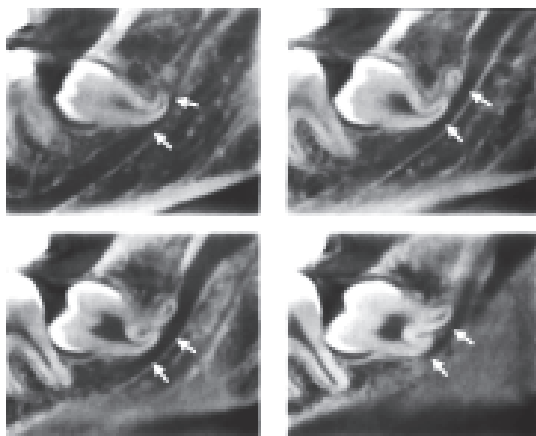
A series of four high-resolution 3DAccuitomoTM, cone beam CT images of 8 showing the relationship of the roots to the ID canal
